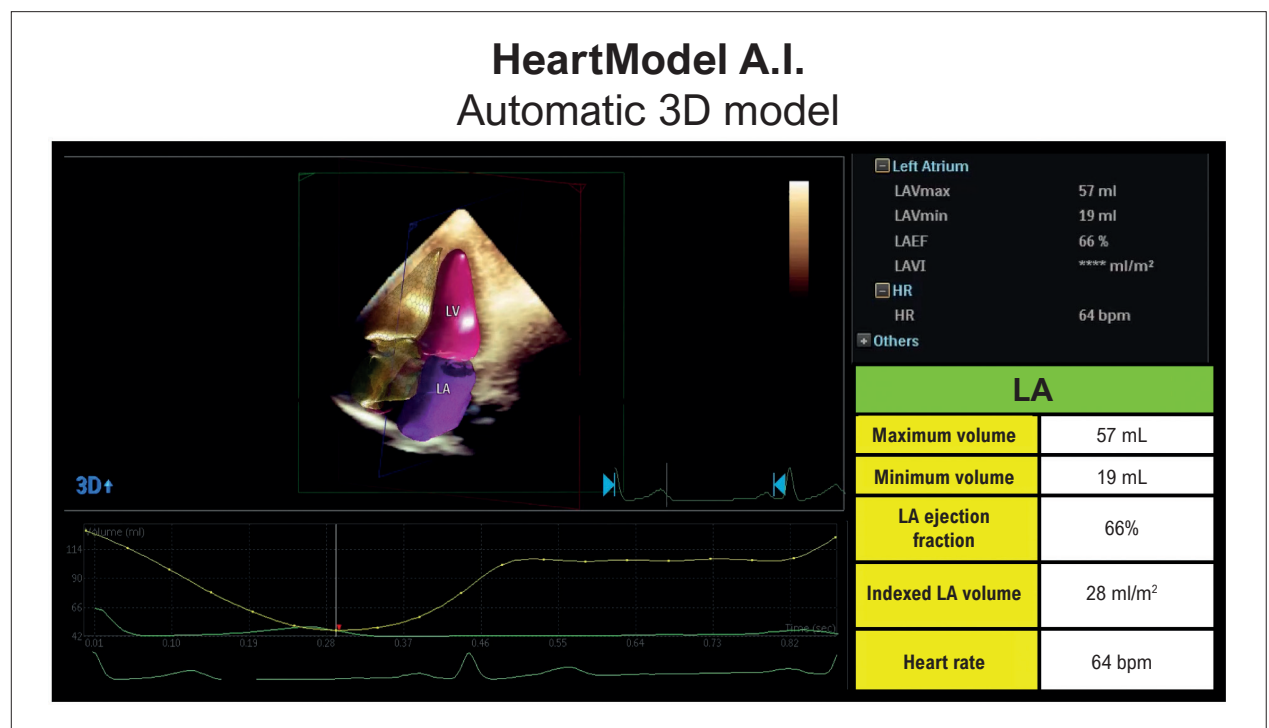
Automated 3D transthoracic quantification of left heart chambers using specific HeartModel A.I. software. LA: left atrium; 3D: three-dimensional.
